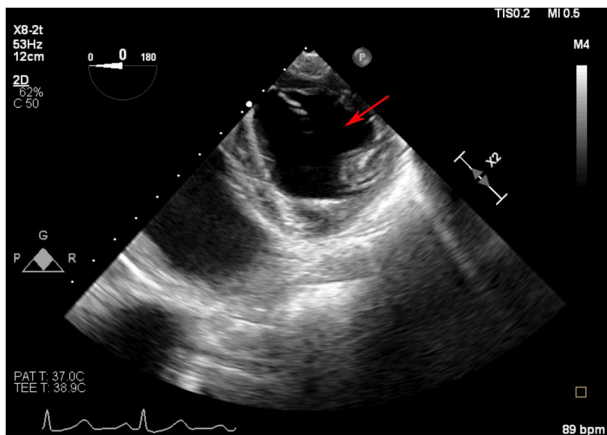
A 2D transesophageal echocardiography image obtained by the authors from a 14-year-old male patient undergoing lung transplantation for obliterative bronchiolitis. The image demonstrates an enlarged RV alongside a relatively compressed LV, with the D-shaped deformation of the LV serving as a hallmark of RV pressure overload. The D-shaped LV is marked by the red arrow. RV, right ventricle; LV, left ventricle.
